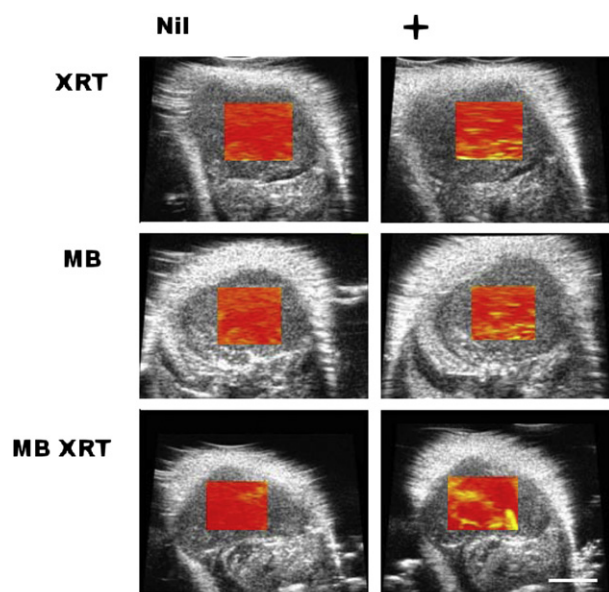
Representative parametric images of treatment effects. Nil column indicates data before treatment, + column indicates data 24 h after treatment, radiotherapy alone (XRT) indicates 8 Gy radiation, microbubble (MB) indicates treatment with ultrasound-stimulated microbubbles and MB XRT indicates combined treatment. The scale bar represents 3 mm. The colour map indicates a change of 6 dB from red to yellow.
